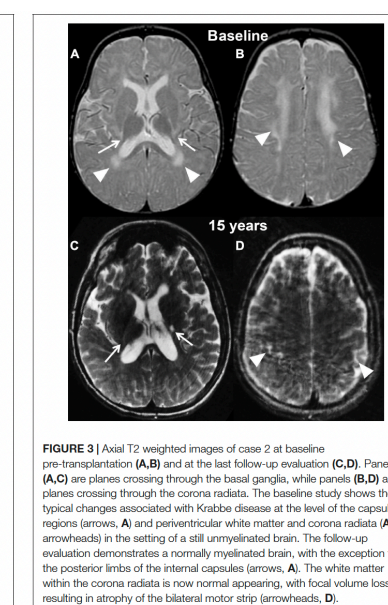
Case 2: Axial T2-weighted images of Case 2 at baseline (A,B) and at 15 years follow-up (C,D). Panels (A,C) are slices crossing through the basal ganglia, while panels (B,D) are slices crossing through the corpus callosum. The baseline study shows the typical changes associated with Krabbe disease at the level of the capsular region (arrows, A) and periventricular white matter and corpus callosum (A, arrowheads) in the setting of a still unmyelinated brain. The follow-up examination demonstrates a normally myelinated brain, with the exception for the posterior horns of the internal capsules (arrows, A). The white matter within the corpus callosum is now normal appearing, with focal white lines resulting in atrophy of the bilateral motor strip (arrowheads, D).
